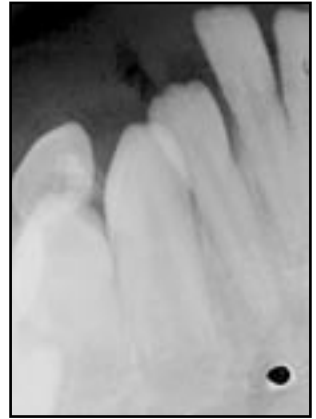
Case 2: Radiograph showing a radiolucent unilocular area circumscribing the crown of permanent incisor tooth.
